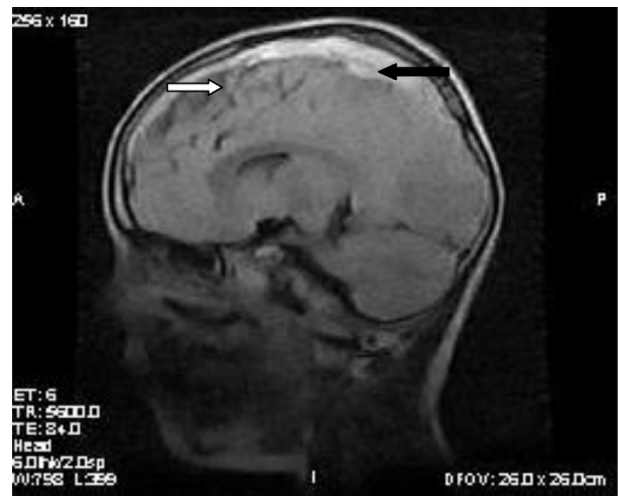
CT Scan brain showing thrombosis of the superior sagittal sinus.
